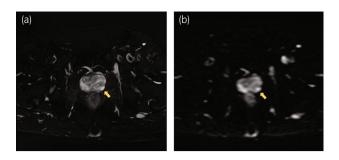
MRI image of the prostate. Low-intensity signals on a T2-weighted image (a) and high-intensity signals on a diffusion-weighted image (b) in the left peripheral zone.
